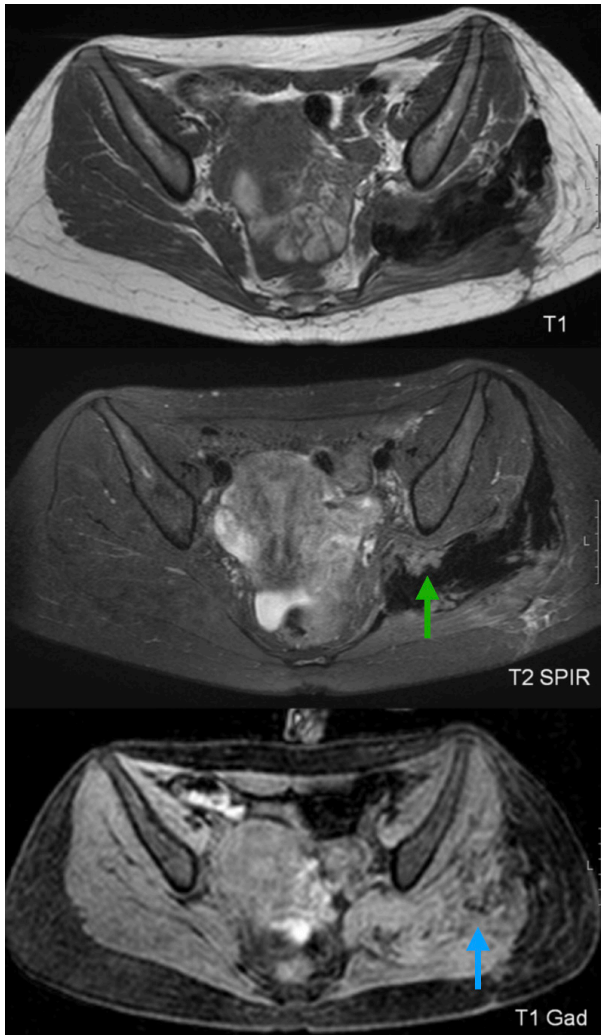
Deep “active” fibromatosis of the left gluteus muscle in a 49-year-old male. Axial MR images showing an infiltrative mass in left gluteal region with heterogenous low signal intensity on T1-weighted and T2-weighted images. High intensity signal areas on T2-weighted images (green arrows) and avid enhancement (blue arrows) suggest “active”/first stage disease.
